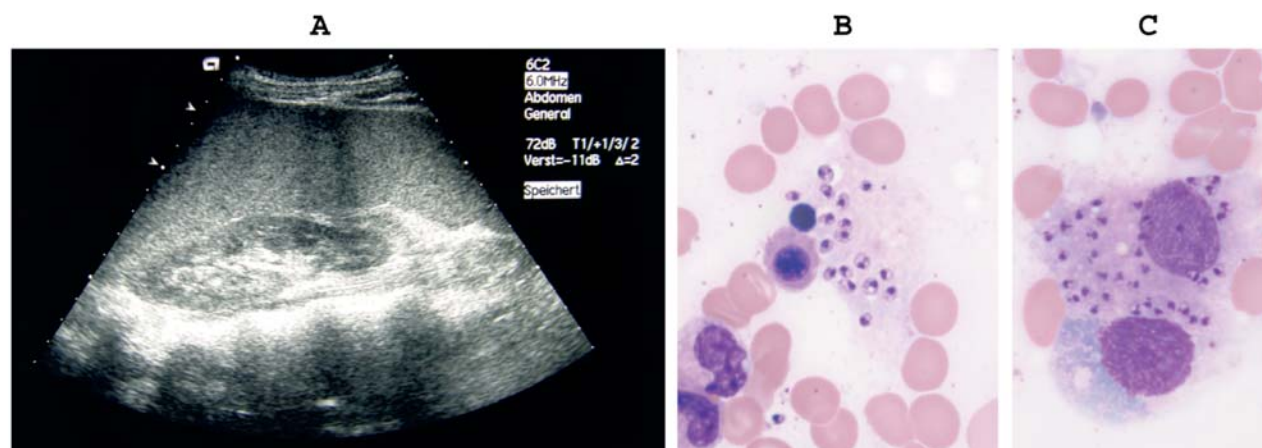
Ultrasound of splenomegaly (~ 20 cm) [A], bone marrow biopsy revealed numerous protozoan parasites (*Leishmania* spp.) either extracellularly [B] or within bone marrow macrophages [C]
